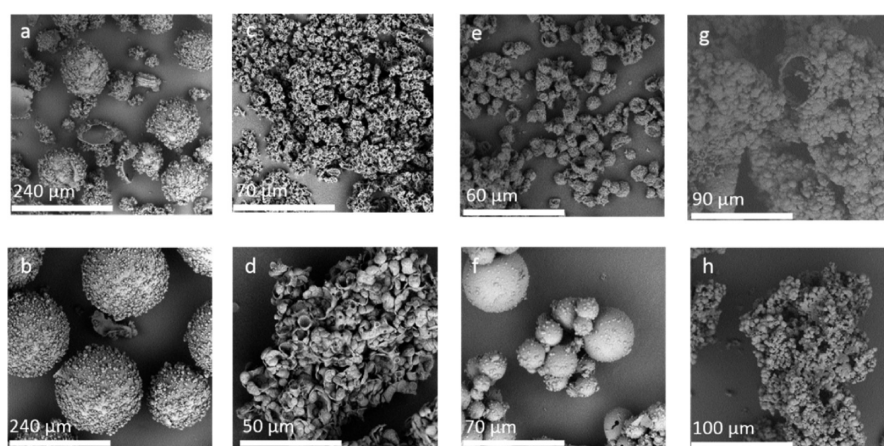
Microcapsules with different surfactants at pH = 4, core/shell = 2.82, 2.5% surfactant at different scales: (a) PSMA, (b) SDS, (c) PVA, and (d) PSMA/PVA (50/50 by weight).
